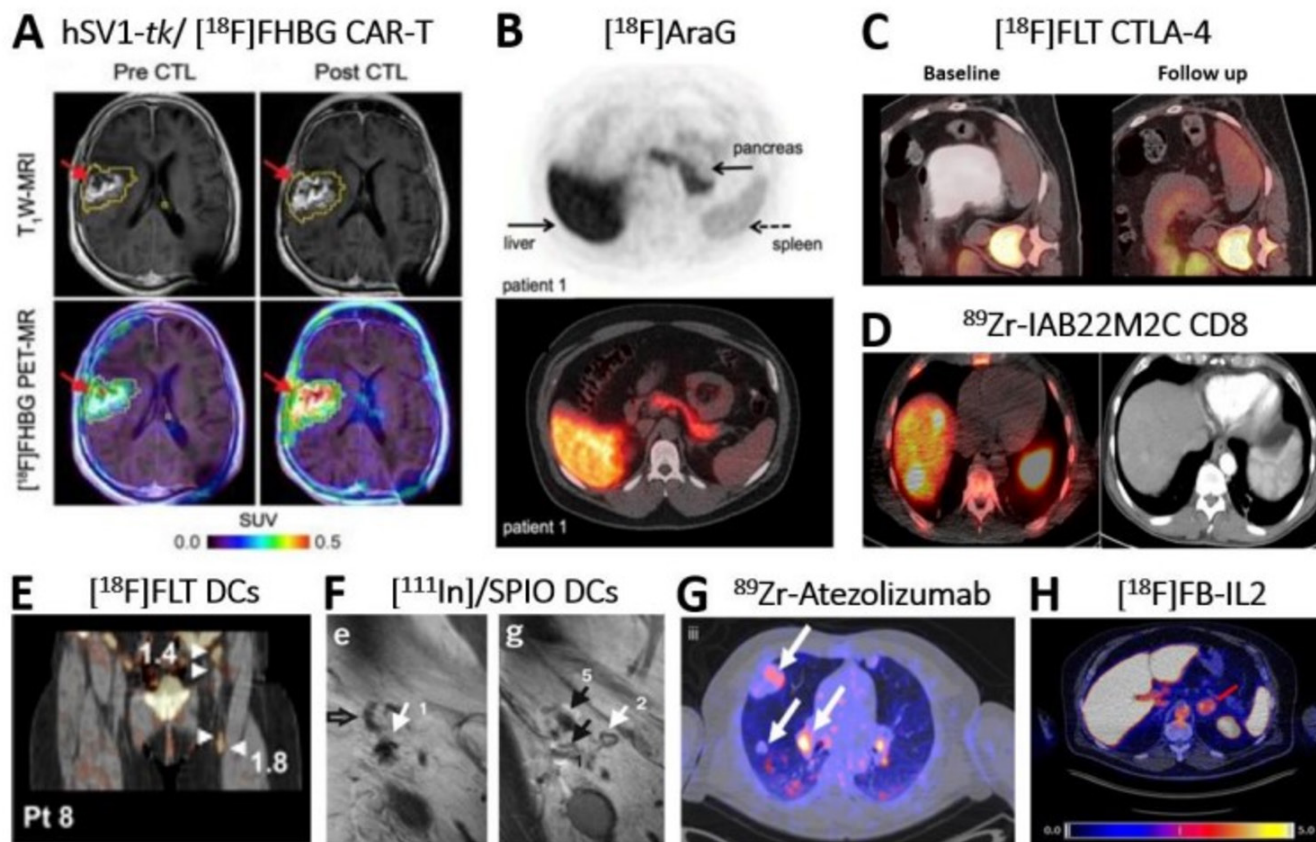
Clinical application of direct and indirect molecular imaging in cell-based Immunotherapy. (A) Non-invasive reporter gene imaging of IL-13 zeta-kinase-directed and HSV1-*tk*-expressing CAR-T cells in a 66-year-old patient with recurrent frontoparietal glioblastoma. [^{18}F]FHBG PET-CT revealed increased uptake after CAR-T cells infusion 1-week post infusion. Tumor extent was assessed by T₁W MRI (top row) before and after CAR-T intratumoral infusion. Images were superimposed with [^{18}F]FHBG PET (bottom row).³¹ (B) Image of a healthy volunteer showing [^{18}F]AraG tracer *in vivo* distribution 60 min post intravenous administration of 189.07 MBq.⁹⁹ The tracer exhibits hepatobiliary and renal clearance. Shown are transversal PET (top) and fused PET-CT (bottom). (C) [^{18}F]FLT PET-CT imaging revealed T cell splenic proliferation in a patient with metastatic melanoma undergoing a durable regression post anti-CTLA-4 (tremelimumab) treatment.⁵⁴ Baseline scan (left) was compared with a 3-month follow-up scan (right). (D) ^{89}Zr -IAB22M2C PET-CT of CD8+T cells performed in a patient with hepatocellular carcinoma on immunotherapy for 12 weeks prior to imaging.^{39,40} Zr-IAB22M2C-positive lesions in the PET-CT merge (left image) correspond to two liver metastases (left side), spleen (right side) and bone marrow (middle). Additional uptake was seen also in three abdominal lymph node metastases. CT alone is in right image. Images acquired 24 hours post tracer injection. (E) [^{18}F]FLT PET-CT visualizes immune responses in four LNs (see arrows) 3 days after intranodal delivery of [^{111}In]/SPIO-labeled and antigen-loaded DCs and 1 hour after tracer injection.⁶² In fact, tracer retention was observed in the injected In and the three draining LNs. (F) *In vivo* migration of [^{111}In]/SPIO-labeled dendritic cells from LN1 (site of injection; arrow 1/e) to other LNs (arrows 5/g) using MRI.⁶³ Open arrow in left image (E) indicates empty In (NO SPIO); closed black arrow in right image (G) indicates In positive for SPIO. Images taken 2 days post intranodal injection of DCs. (G) ^{89}Zr -Atezolizumab PET revealed uptake in different tumor lesions (white arrows) in one representative patient 7 days postinjection.¹⁰⁰ Pronounced uptake heterogeneity was seen within the same patient. (H) [^{18}F]FB-IL2 uptake corresponding to activated tumor-infiltrating T cells at an adrenal gland metastasis (red arrow) in a representative melanoma patient undergoing immune checkpoint inhibitor therapy (SUV_{max} of 5.2).³⁷ All patients enrolled in this study received intravenous bolus injection of ~200 MBq [^{18}F]FB-IL2 in 5 min. Transversal PET-CT image shown. All figures adapted with permission from publishers. CAR, chimeric antigen receptor; DC, dendritic cell; LNs, lymph nodes; SPIO, superparamagnetic iron oxide; PET, positron emission tomography.
